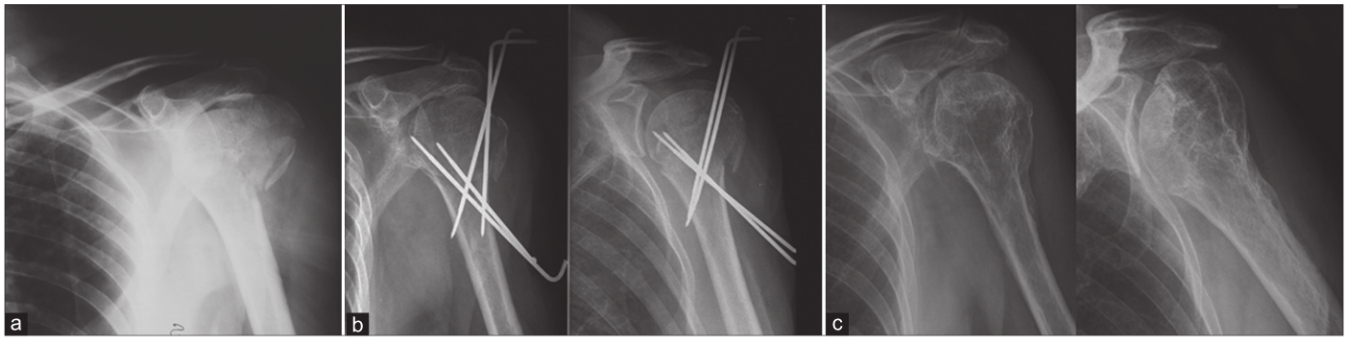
X-ray (anteroposterior view) left proximal humerus in a 61-year-old man showing (a) 3 part proximal humerus fracture; (b) postoperative X-rays with well aligned fragments and k-wires *in situ*; (c) X-rays at 5 years followup with well healed and remodeled proximal humerus
